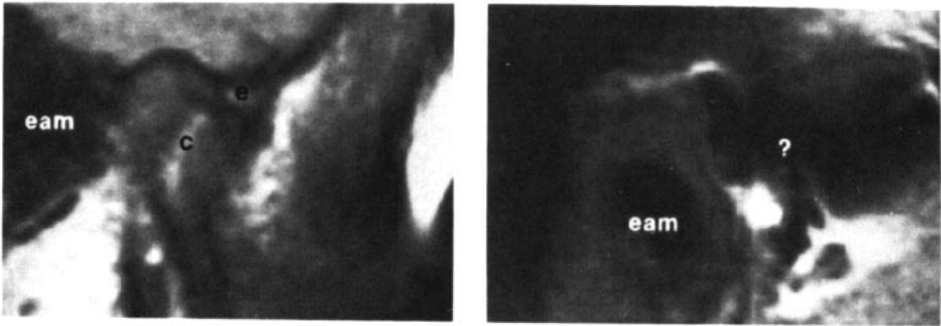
Magnetic resonance images of undiagnosable temporomandibular joints.
